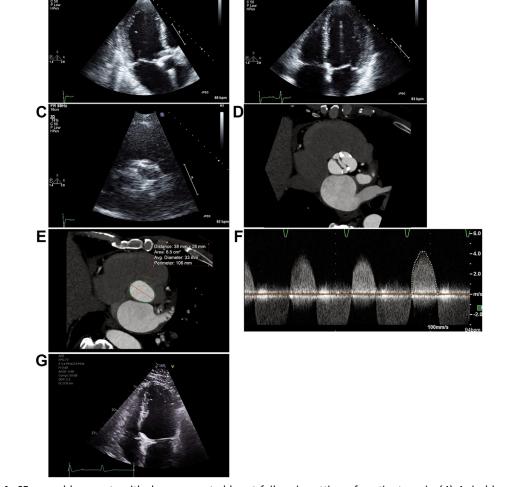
65-year-old presents with decompensated heart failure in setting of aortic stenosis. (*A*) Apical long axis view shows severely reduced left ventricular systolic function with hyperechoic and thickened aortic valve leaflets with decreased excursion. (*B*) Apical 4 chamber view show reduced left and right ventricular systolic function. (*C*) Aortic valve morphology is difficult to delineate on this short-axis view. (*D*) 4D CTA showed a bicuspid aortic valve with asymmetric calcification of the sinuses. (*E*) On CTA, the aortic annulus was enlarged, which favored surgical versus transcatheter aortic valve replacement. (*F*) Continuous wave Doppler from the right upper sternal border is compatible with severe aortic stenosis with a prolonged acceleration time and increased acceleration time (AT) to ejection time (ET) ratio. (*G*) Left and right ventricular systolic function is improved after surgical aortic valve replacement.
